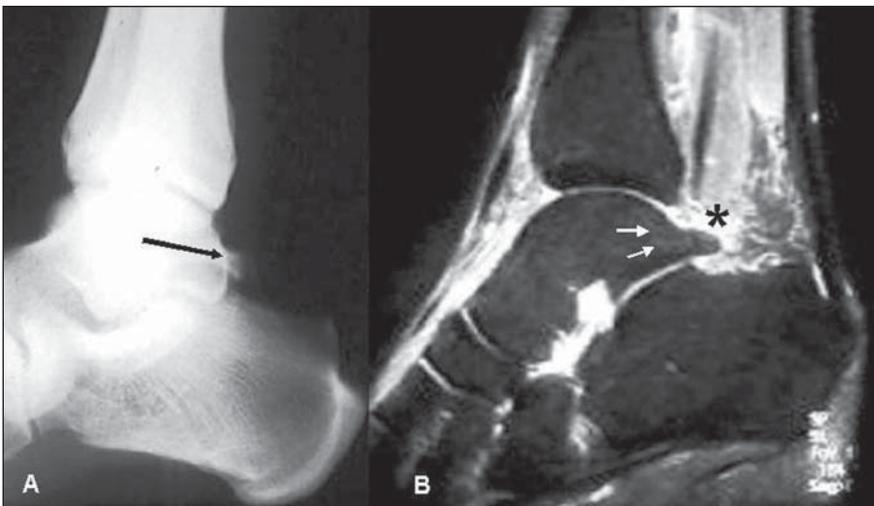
Lateral ankle radiography (A) and sagittal MRI fat-suppressed proton-density-weighted (B) images demonstrate prominent posterior talar process, Stieda's process (long arrow) with subtle bone marrow edema (short arrows). Additionally, soft-tissue edema is observed between the posterior rim of the tibial epiphysis and the posterior talar process (asterisk).
